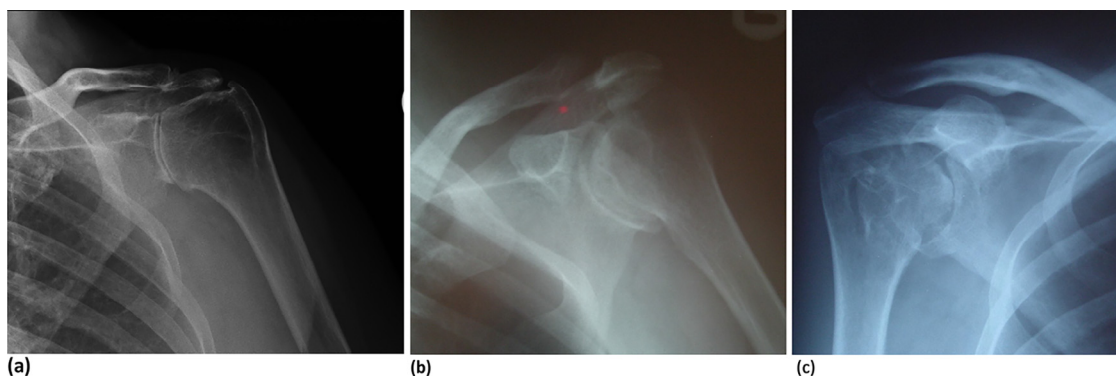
Preoperative anteroposterior radiographs of 3 patients. (a) Larsen IV changes with superior head erosion and advanced acromioclavicular joint disease. (b) Larsen IV changes with glenoid erosion, early metaphyseal notching, and greater tuberosity overgrowth. (c) Larsen V changes; severe distortion of the humeral head and glenoid erosion.
